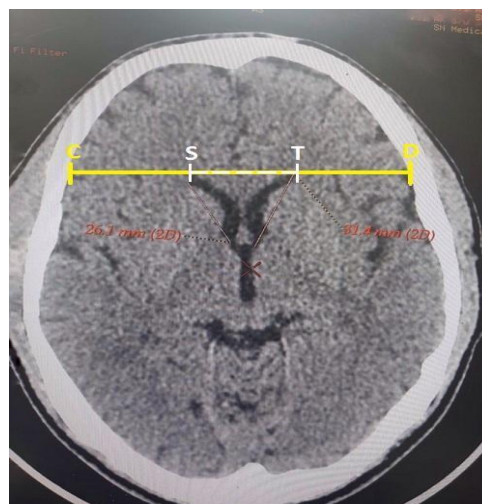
Axial CT image of the brain at the level of Caudate nucleus when the ventricular system is maximum dilated. [21]
